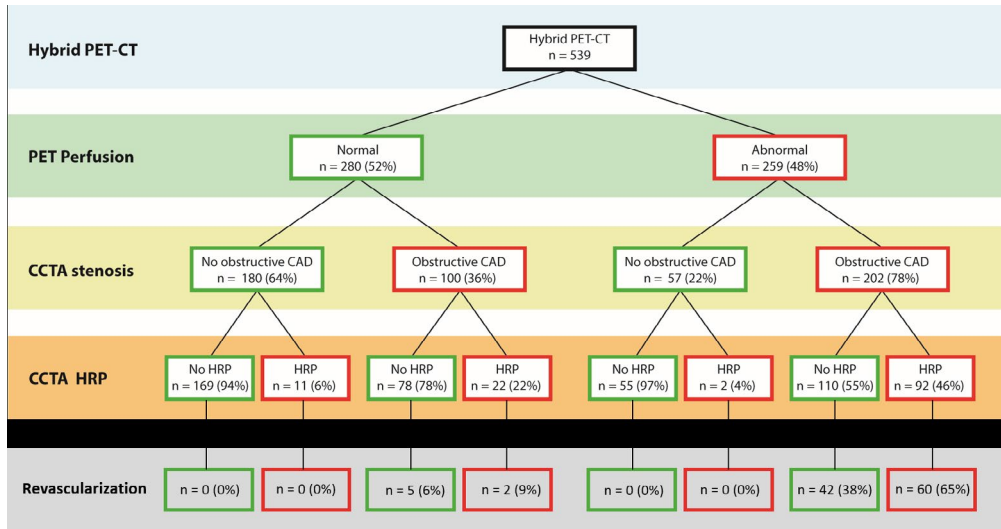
Distribution of hybrid PET-CT findings
